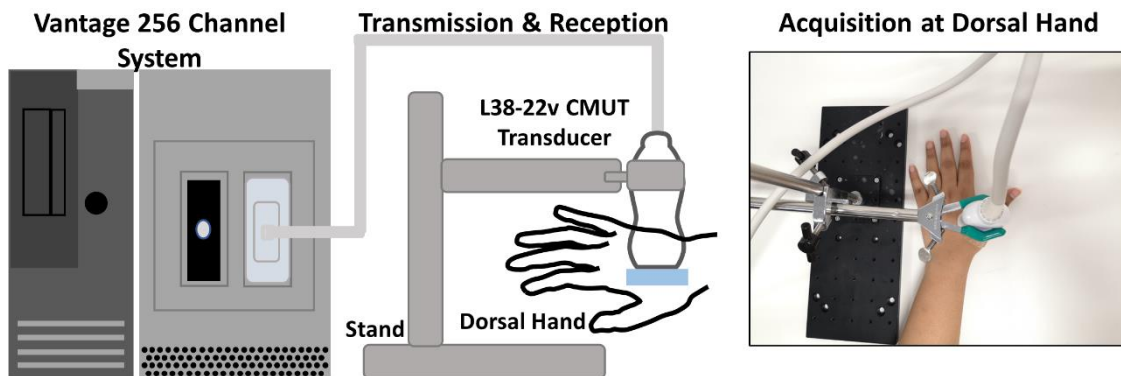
Experimental Setup. © 2022, Ultrasonics, Elsevier
